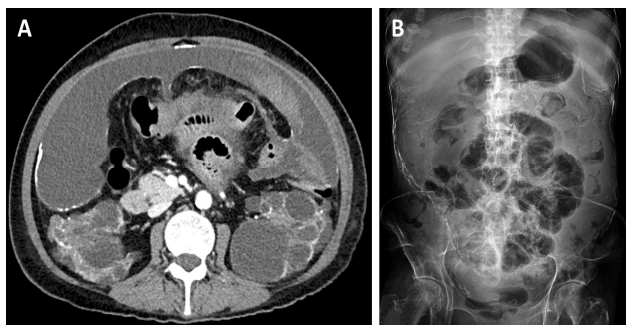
Initial abdominal imaging. (A) Abdominal CT shows EPS accompanied with massive amounts of ascites in an ADPKD patient with numerous renal cysts. (B) Abdominal X-ray shows mechanical ileus and ascites with calcification along the peritoneal membrane.
